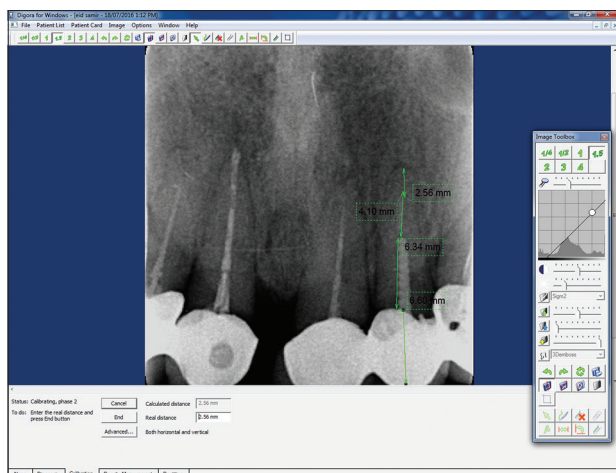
Screenshot of Digora® software showing the required length measurements obtained from periapical radiograph
